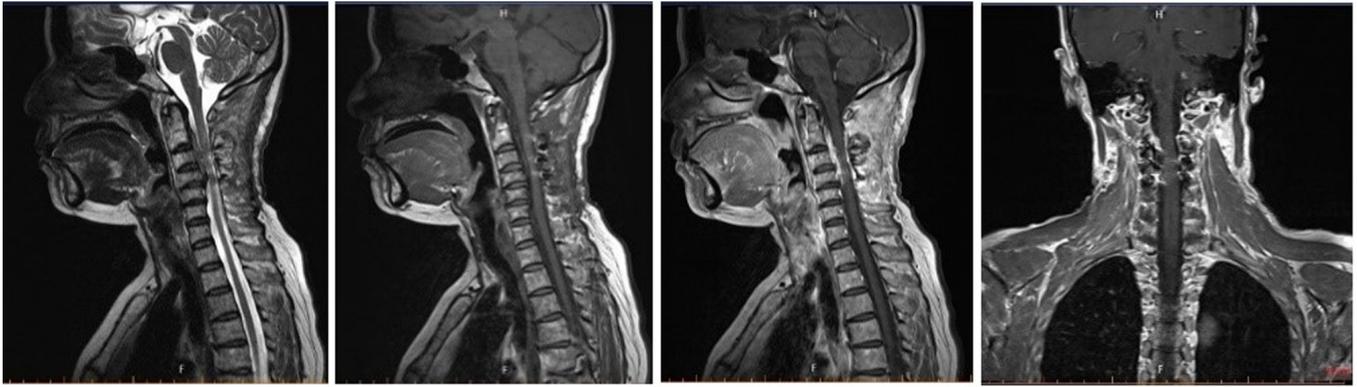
Cervical spine enhanced magnetic resonance imaging in August 2023.
